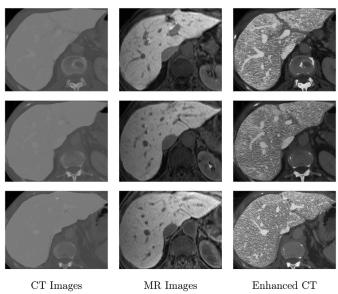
CT, MR and enhanced CT images.
